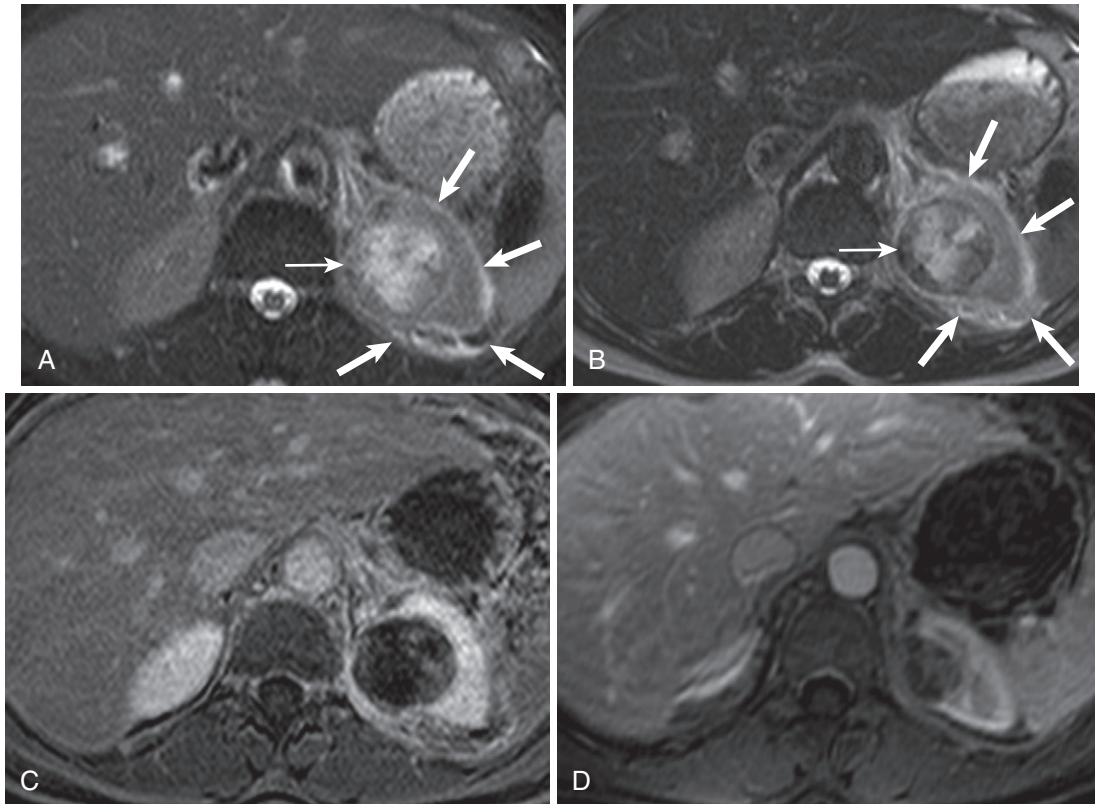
Renal abscess. A, The axial fat-suppressed T2-weighted image shows a heterogeneously hyperintense lesion in the upper pole of the left kidney (*thin arrow* in A and B) associated with perinephric edema (*thick arrows* in A and B). B, The corresponding T2-weighted image without fat suppression exaggerates the internal complex hypointensity not typical of a simple or hemorrhagic cyst. C, The postcontrast image reveals virtual absence of internal signal (minimal internal signal represents debris—also hyperintense on the corresponding unenhanced image [not shown]). D, An axial T2-weighted image from a follow-up examination 1 month later establishes involution and improvement after antibiotic treatment, confirming infectious (and non-neoplastic) etiology.
